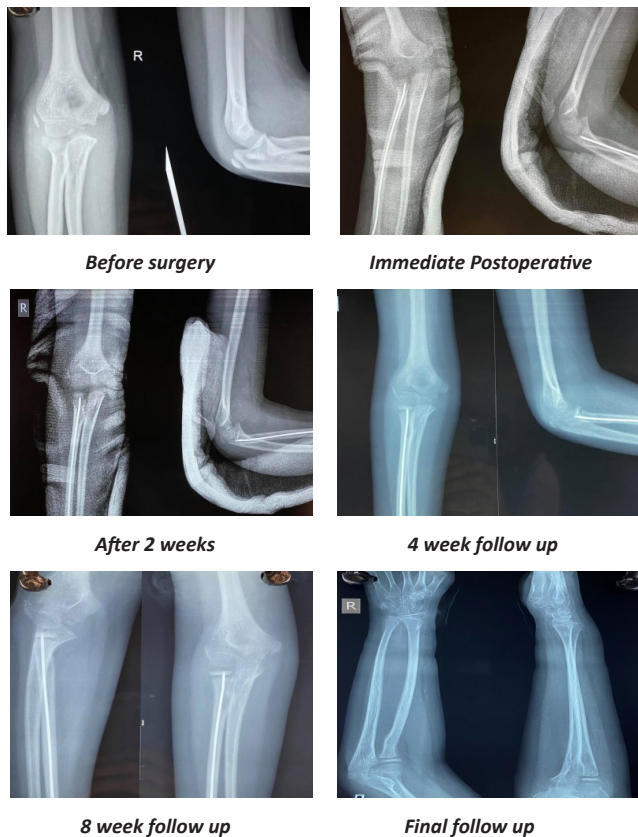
Sequential radiograph till final follow-up
